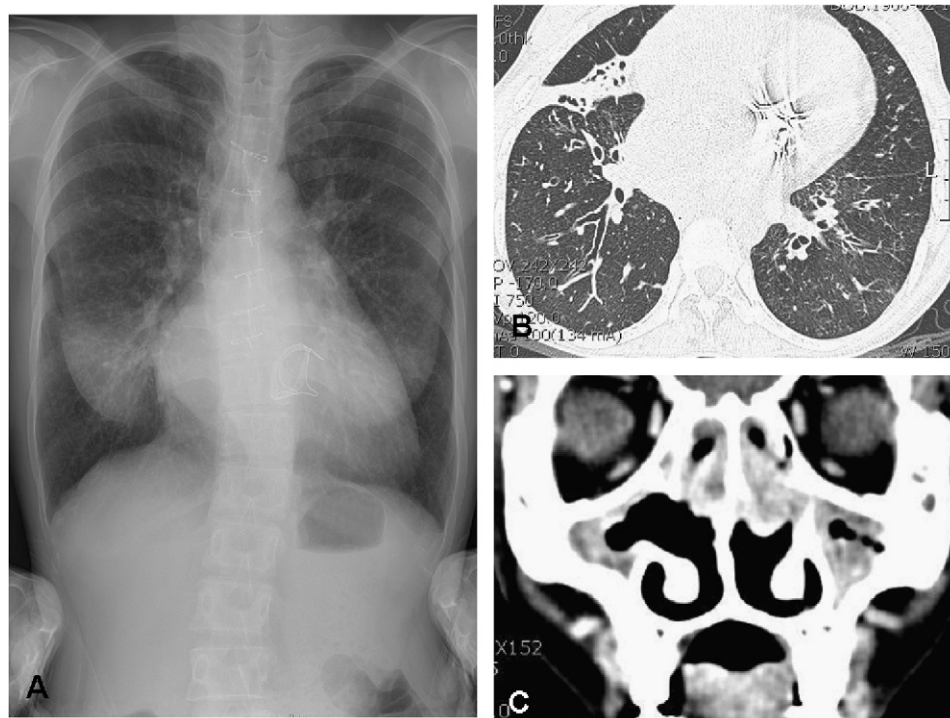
(A) Chest radiograph showing cardiomegaly with levocardia, normal gastric gas bubble on the left side and coarse reticular opacities through both lung fields suggestive of tubular bronchiectasis. (B) High-resolution computed tomography of the chest showing bronchiectatic changes in both lobes. (C) Computed tomographic scan of the paranasal sinuses showing chronic pansinusitis with polyps along the nasal septum.
